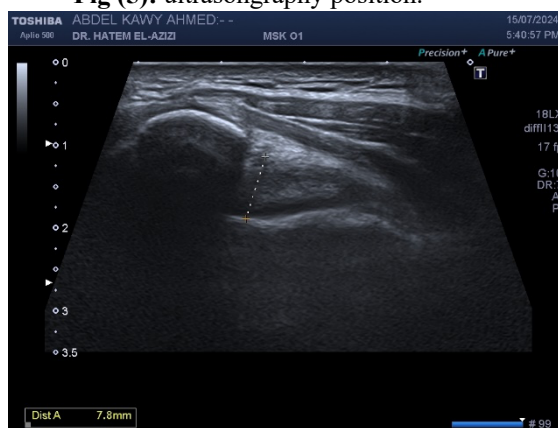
ultrasonography image of supraspinatus tendon thickness.
